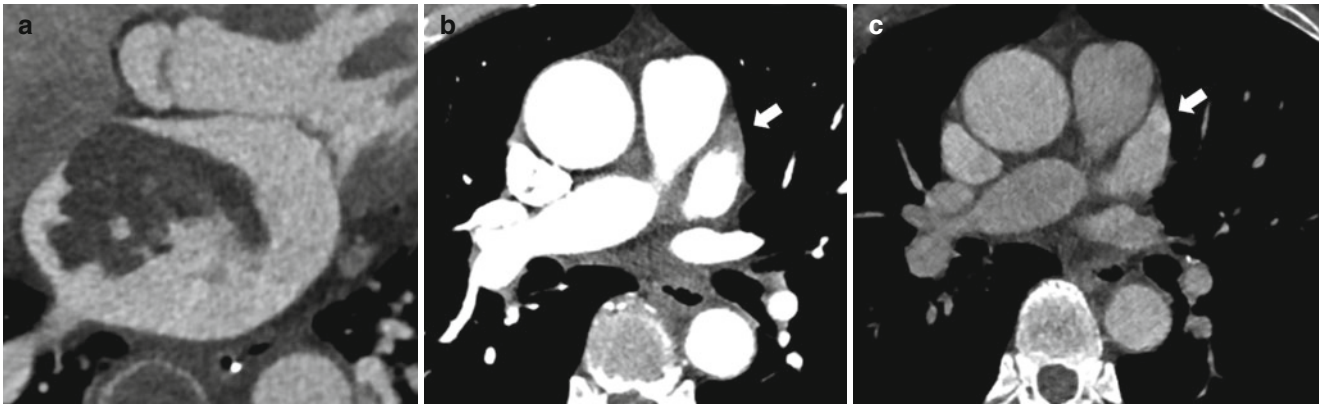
Left atrial thrombus. Contrast material-enhanced CT image (a) shows filling defects in the left atrium, suggestive of thrombus. But, (b) the heterogeneous attenuation from unmixed blood and contrast
